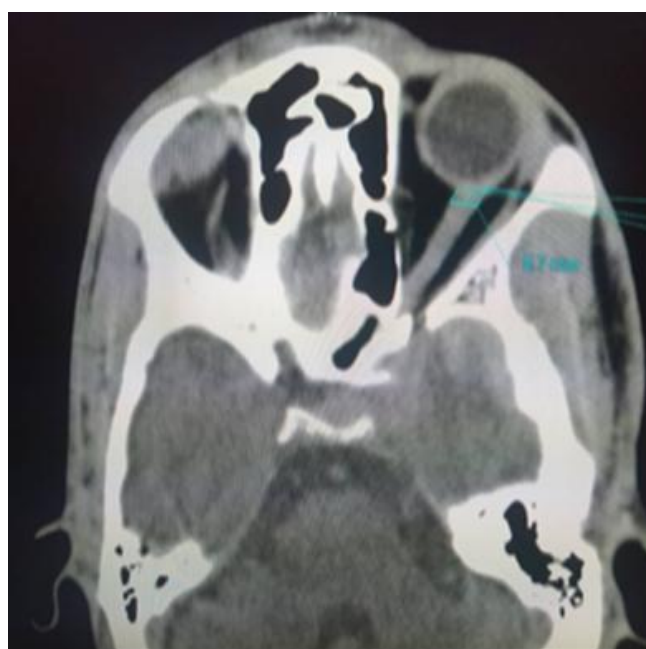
Axial CT of left temporal lobe contusion with increased ONSD
